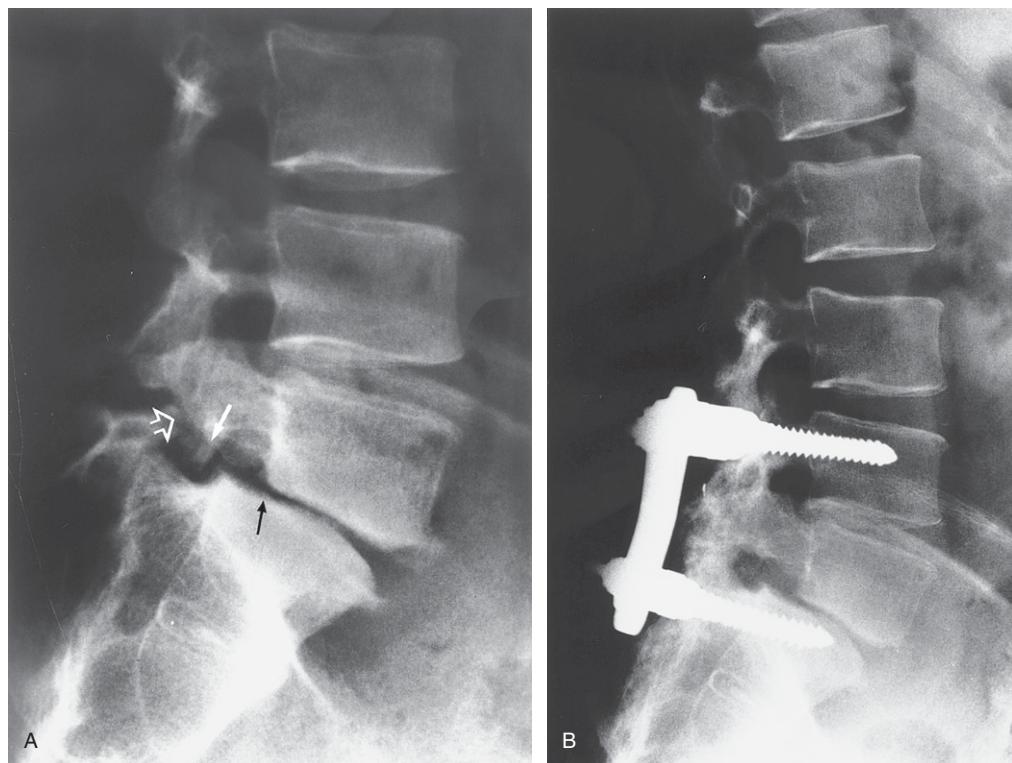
(A) Lumbar spine lateral plain X-ray image showing the grade 1 spondylolisthesis of L5 on S1 with advanced thinning of the intervertebral disc at this level and osteophytic lipping at the anterior margins of the L5 and S1 bodies. The open arrow shows the fractured pars interarticularis. The white arrow indicates the bone spicule projecting into the right L5-S1 intervertebral foramen. The black arrow shows the degree of spondylolisthesis, i.e. the L5 body has moved approximately one quarter of the distance along the sacral body, hence the grade 1 classification according to Meyerding's (1932) classification (Yochum & Rowe 1996, Giles 1997). (B) A post-surgical lumbar spine lateral plain X-ray image showing the pedicle screw fixation from L4 to S1 and the patent L5-S1 intervertebral foramen following removal of the bony spicule.
